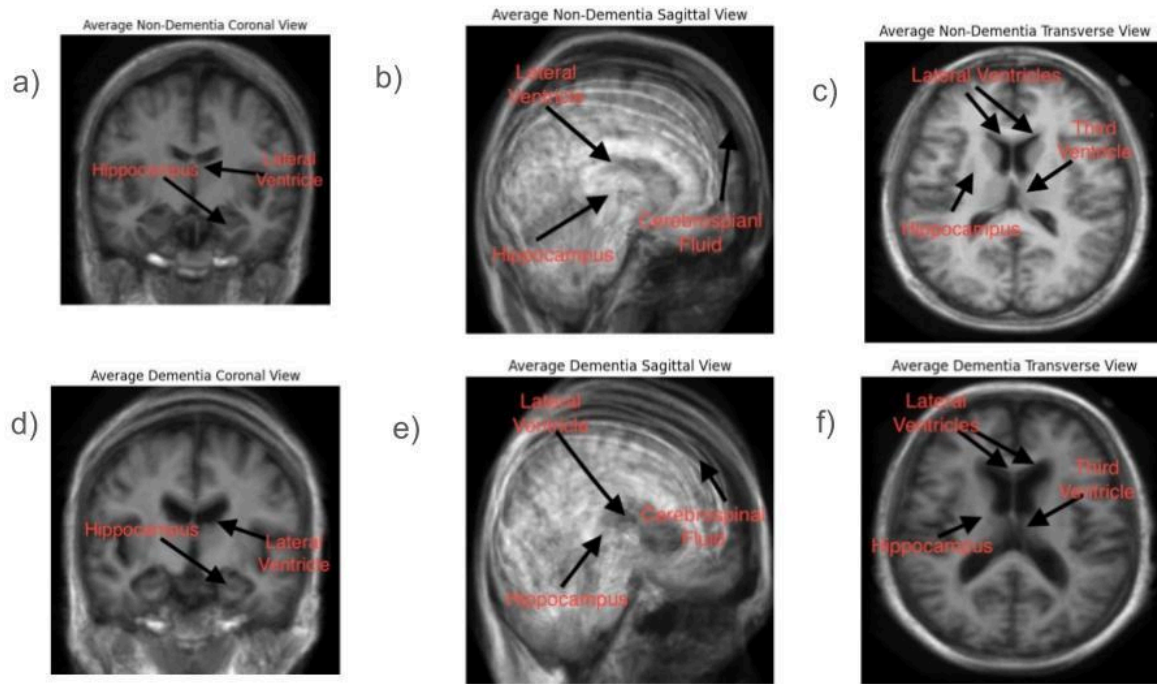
Panels a-f are MRI's scans obtained from Oasis 1 [12]
